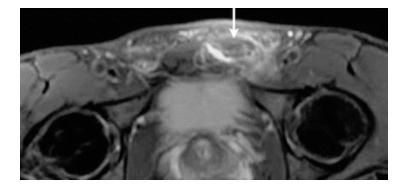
Axial fat-suppressed T2-weighted MRI shows high signal intensity area due to left rectus abdominis strain (arrow)
